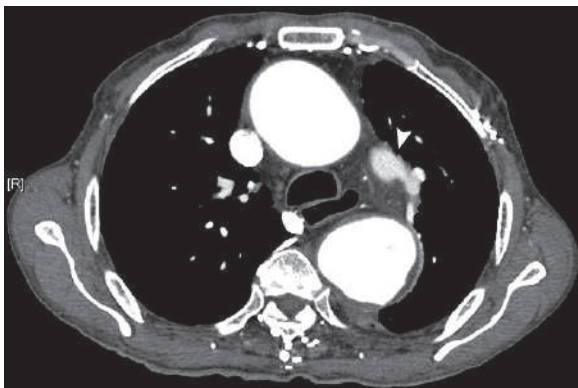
Axial thoracic CTA demonstrates TAA with fresh blood leak into the mediastinum (arrowhead)
